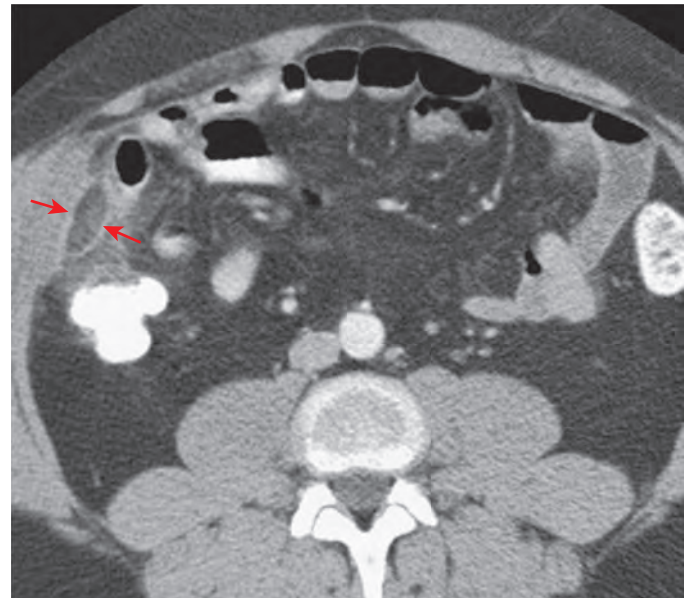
Right-sided epiploic appendagitis. On enhanced CT, the inflamed epiploic appendage (arrows) is identified as a homogeneous oval structure surrounded by a thickened, high-attenuation rim of visceral peritoneum contiguous with the ascending colon.
